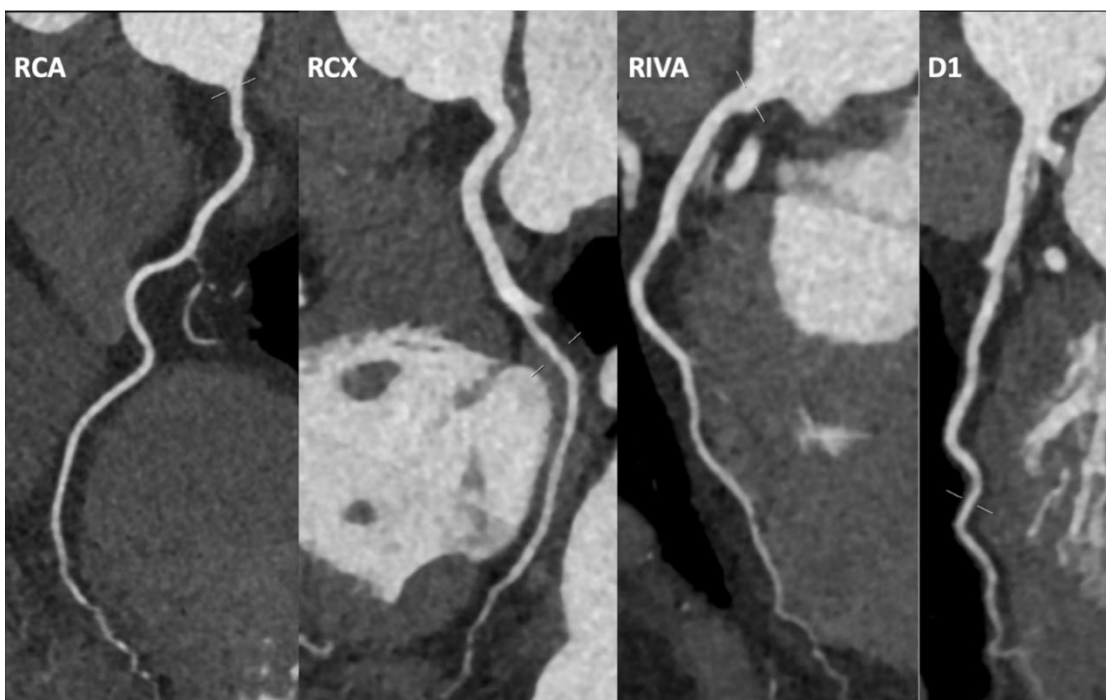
Coronary CT at follow-up (RCA = right coronary artery; RCX = Ramus circumflexus; RIVA = Ramus interventricularis anterior; D1=Ramus Diagonalis 1)
